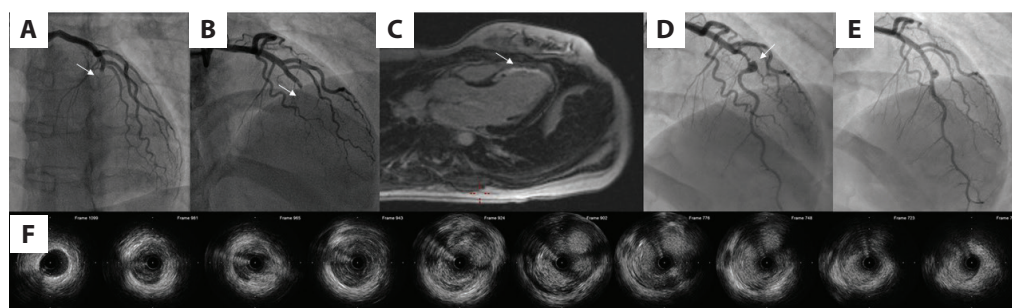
A. Anteroposterior cranial view of LCA. Acute occlusion of LAD artery (arrow). B. RAO view of LAD after 2 days with persistent LAD occlusion (arrow). C. Cardiovascular magnetic resonance, 4-chamber view. Late gadolinium enhancement of the interventricular septum and apex area (arrow). D. RAO view of LAD after 4 months with patent severe stenosed LAD and aneurysm in the middle segment (arrow). E. IVUS imaging of middle segment of LAD. F. RAO view of LAD after percutaneous coronary intervention with stent implantation in the middle segment. Abbreviations: IVUS, intravascular ultrasound; LAD, left anterior descending; LCA, left coronary artery; RAO, right anterior oblique
